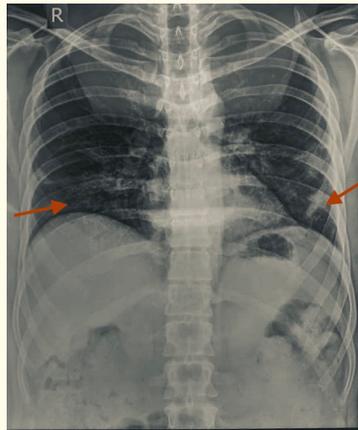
Chest roentgenogram showing B/L lower zone patchy infiltration.
